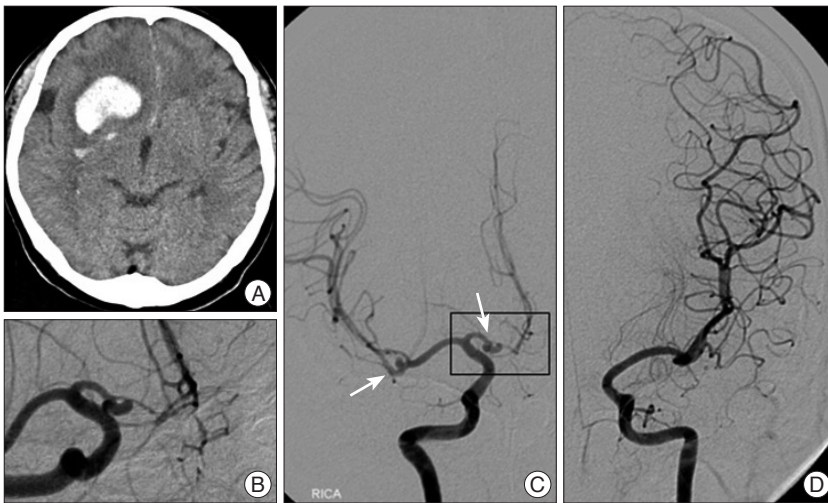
A : Computed tomography scan showing a large intracerebral hemorrhage in right side frontal lobe extending to basal ganglia. Subarachnoid hemorrhage was also identified at the anterior falx and sulci of medial frontal lobes. B : Angiography revealing an aneurysm arising from the proximal end of fenestrated right A1 segment. C : Right cerebral angiogram showing two aneurysms including one on the proximal end of fenestrated A1 and another on the middle cerebral artery bifurcation. Azygos anterior cerebral artery was visible on the angiogram. D : Left carotid angiogram showing that the right A1 segment is aplastic.
